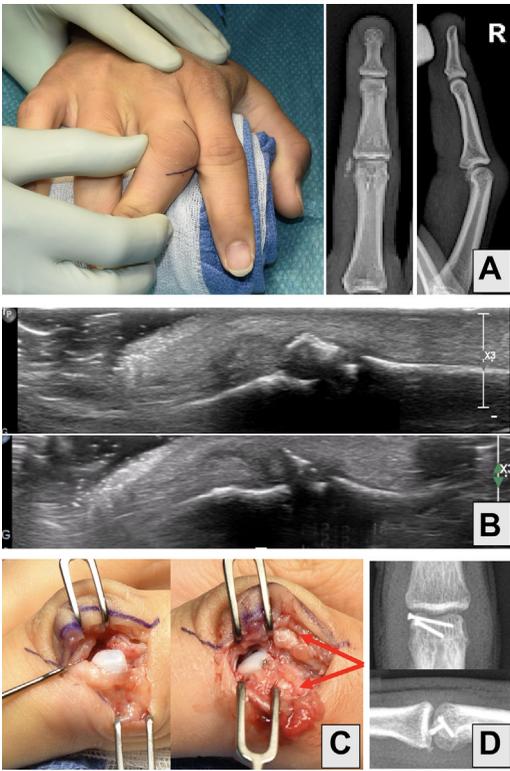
(A) Unstable PIP joint, radiograph with osseous avulsion injury of radial collateral ligament. (B) Longitudinal view of US with intraligament fracture fragment from the base of middle phalanx. (C) Intraoperative 1 mm screw fixation of the thin fragment at the base of middle phalanx with partially divided collateral ligament (arrows). (D) Postoperative radiograph.
